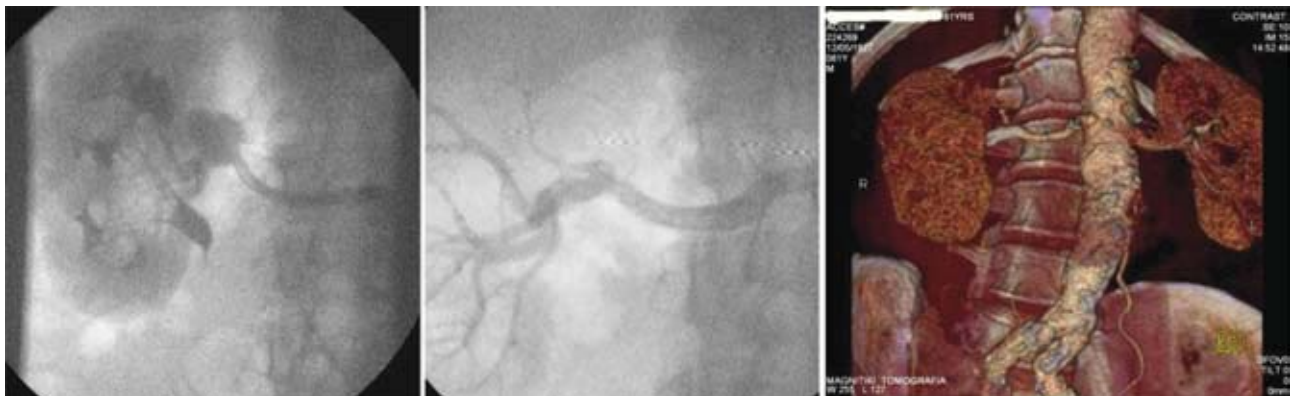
Left panel shows a right renal artery aneurysm, with a side branch arising from the aneurysm sac, feeding the upper pole of the kidney. Middle panel: 1-year follow-up angiography shows exclusion of the aneurysm with patent side branch. Right panel: follow-up CT-angiography at 30 months shows exclusion of the aneurysm with patent side branch.
